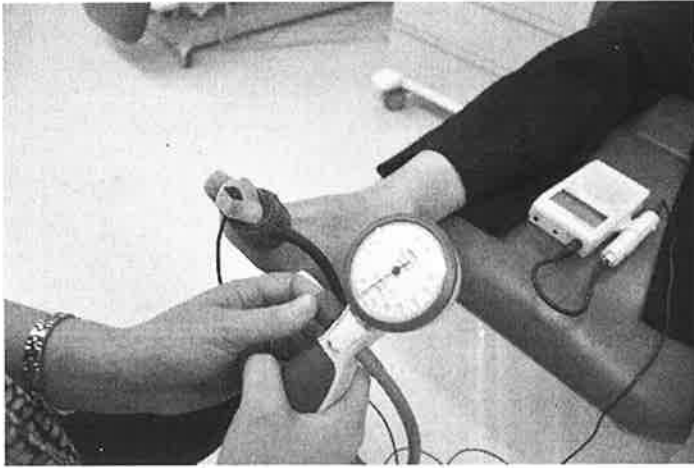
A systolic toe pressure being measured using the manual hand-held photoplethysmography (PPG) method. Continuous wave Doppler can also be used on the digital arteries in lieu of a PPG probe.
